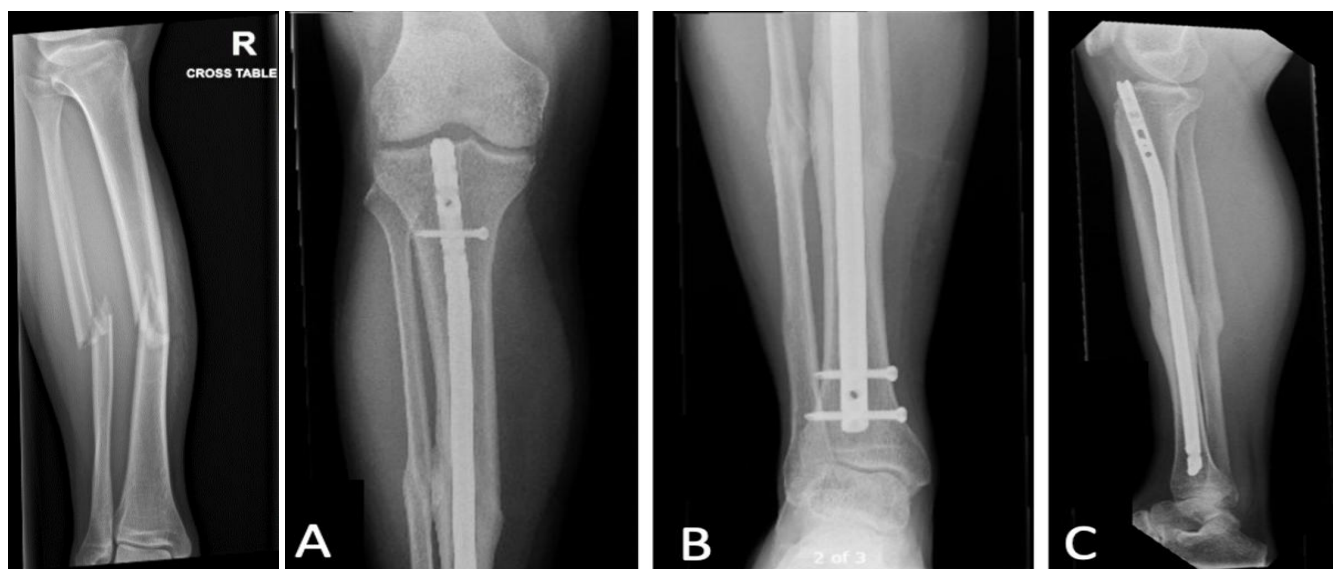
Preoperative radiographic showing midshaft tibia fracture
